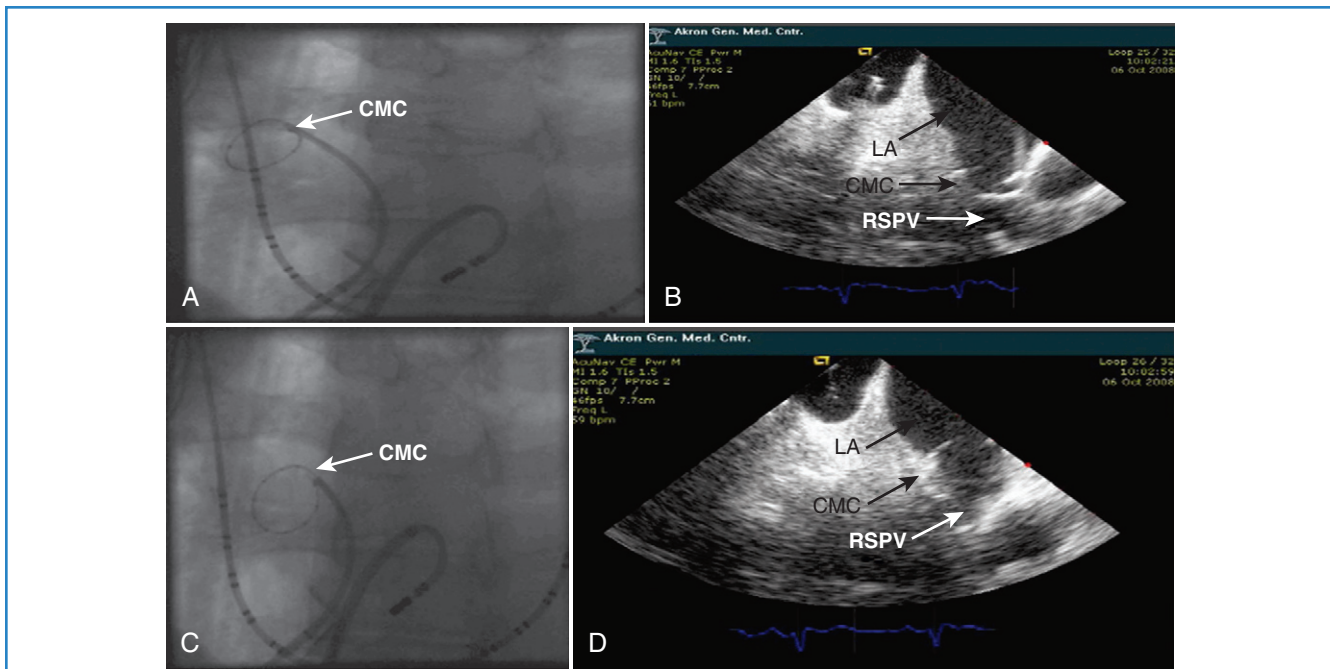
Intracardiac echocardiography (ICE) and corresponding fluoroscopic images demonstrating a distal location of the circular mapping catheter (CMC) within the right superior pulmonary vein (RSPV) (A, fluoroscopic image; B, ICE image) and a more proximal location of the CMC appropriately at the antrum of the right inferior pulmonary vein (C, fluoroscopic image; D, ICE image). The fluoroscopic images are in a left anterior oblique projection. The ICE images show the right inferior pulmonary vein in a longitudinal view. LA, Left atrium.
